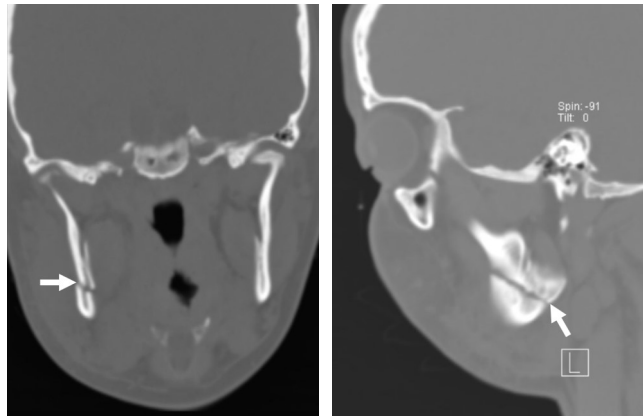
In a 25-year-old male patient, angulus fracture in the right mandible due to fall in a 25-year-old male patient in the coronal (a) and sagittal (b) unenhanced CT images (arrows).
